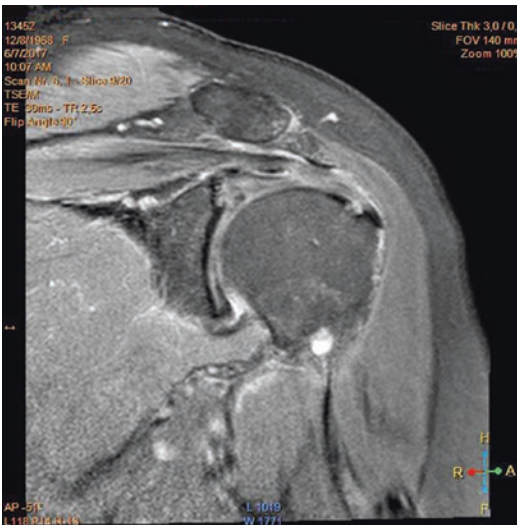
MRI of a right shoulder (coronal view) with a partial-thickness articular-sided tear of the supraspinatus tendon
